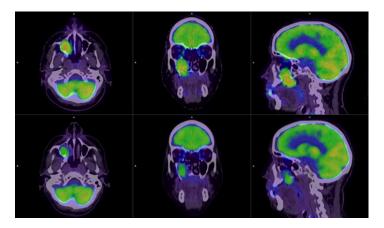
Partial remission (PR): pre-treatment (upper-line) axial, coronal and sagittal PET/CT images show maxillary sinuous tumor penetrated to the bone; pre-treatment SUVmax 7.8. Post-treatment (lower-line) axial, coronal and sagittal PET/CT images show a decrease in SUVmax to 5.1.
